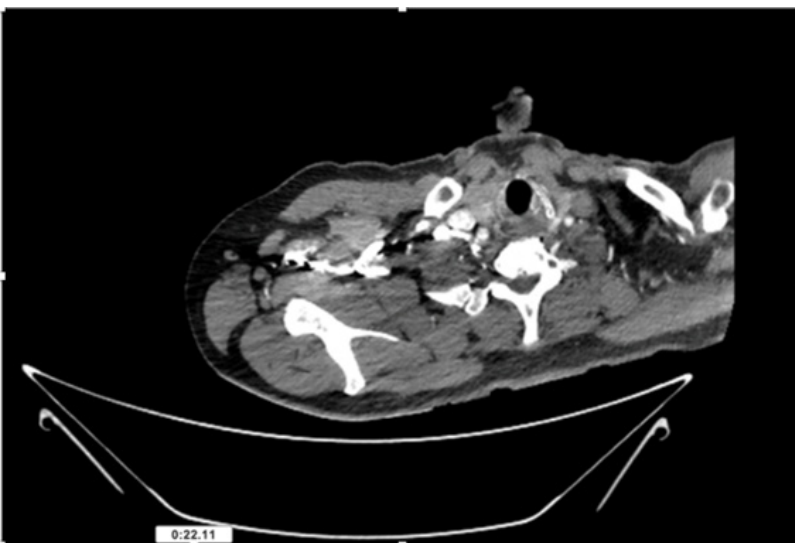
CT Angiogram at neck showing normal brachio-cephalic trunk, common carotid artery, and narrow right subclavian artery.
